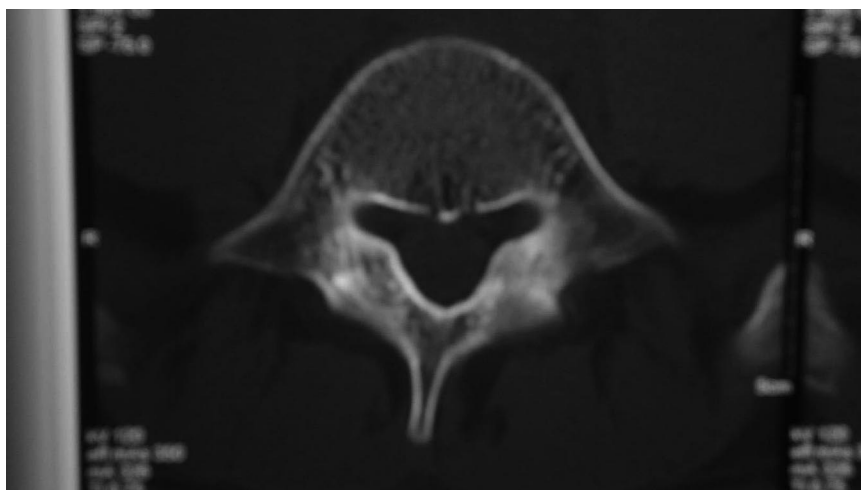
Axial CT of same patient at the same L5 vertebral level indicating resolution of the bilateral pars defect after treatment. Again, the pars defect has resolved bilaterally; however, it is much more easily appreciated on the left.
